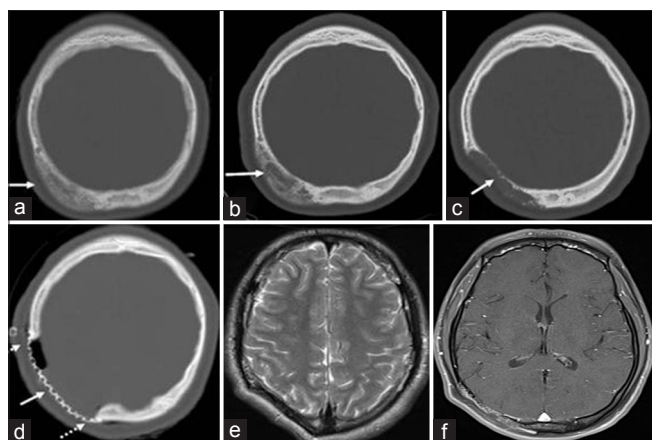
CT scan of the brain from March 16, 2012 (a) shows bony lesion with predominant ground glass appearance which is extracranial. Additional CT on September 14, 2012 (b) and February 21, 2014 (c) shows progression of the bony lesion with increase in the area of lucency. (d) post-op CT showing reconstruction with titanium mesh. (E-f) pre-operative showing extramedullary lesion with dural enhancement
